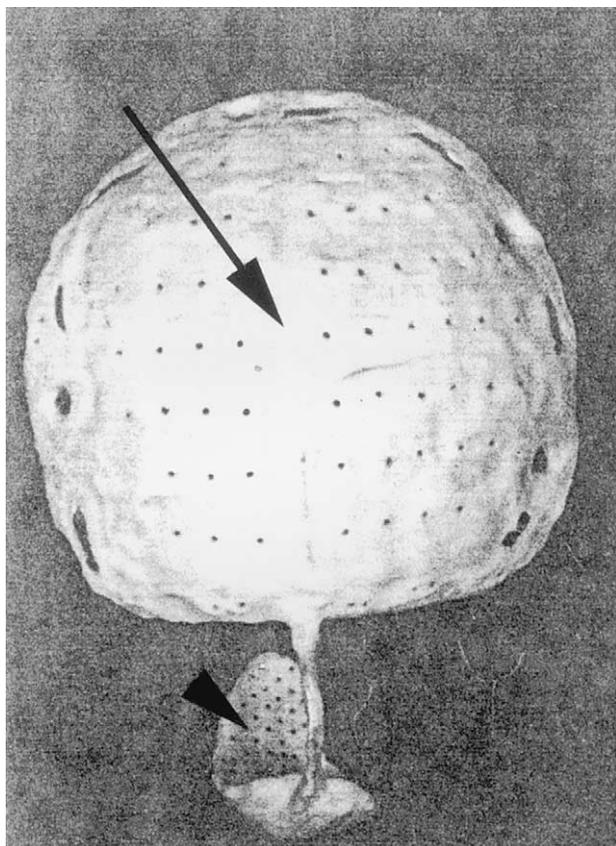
Left: The first chronic cortical visual prosthesis before implantation. The arrowhead points to the electrode array and the arrow to the "array" of radio receivers. Right: X-rays of the same device after implantation. The electrode array (arrow head) is connected to the radio receivers (arrow) through a burr hole (asterisk). (Modified with permission of *Journal of Physiology*.¹⁵)
